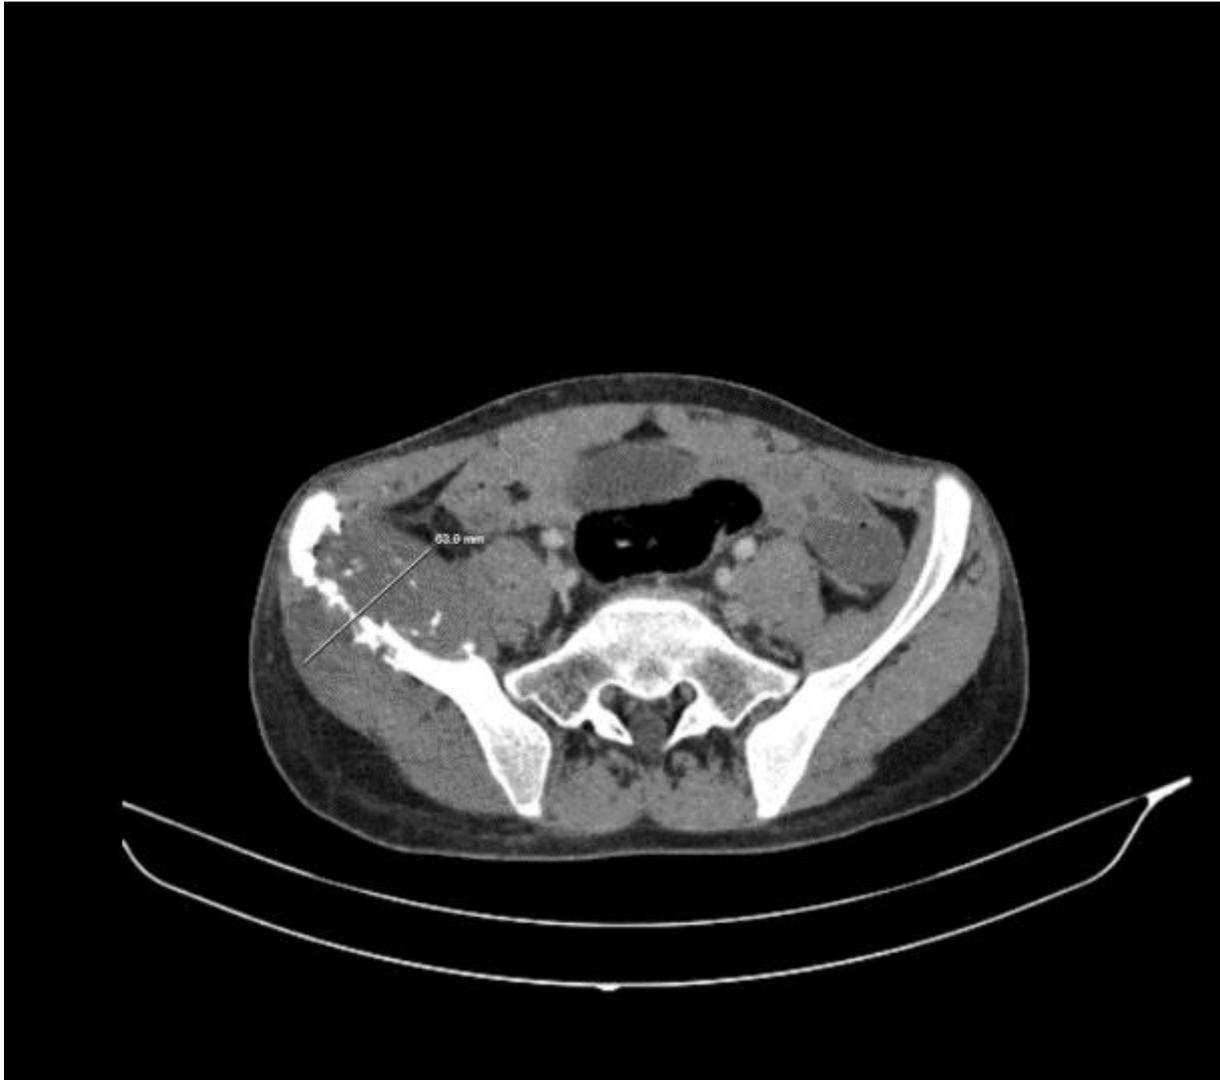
Follow-up axial CT scan three months after completion of radiotherapy showing marked reduction in the size of the right iliopsoas mass and partial reossification of the iliac bone
